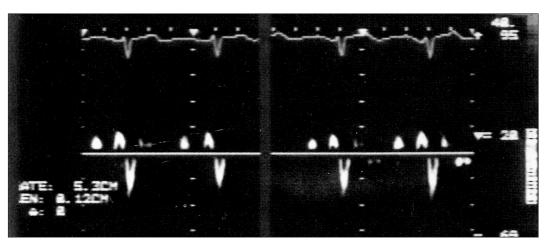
The pulsed wave doppler flow in the left atrial appendage after cardioversion of a patient in sinus rhythm showed a sinuslike flow pattern.
